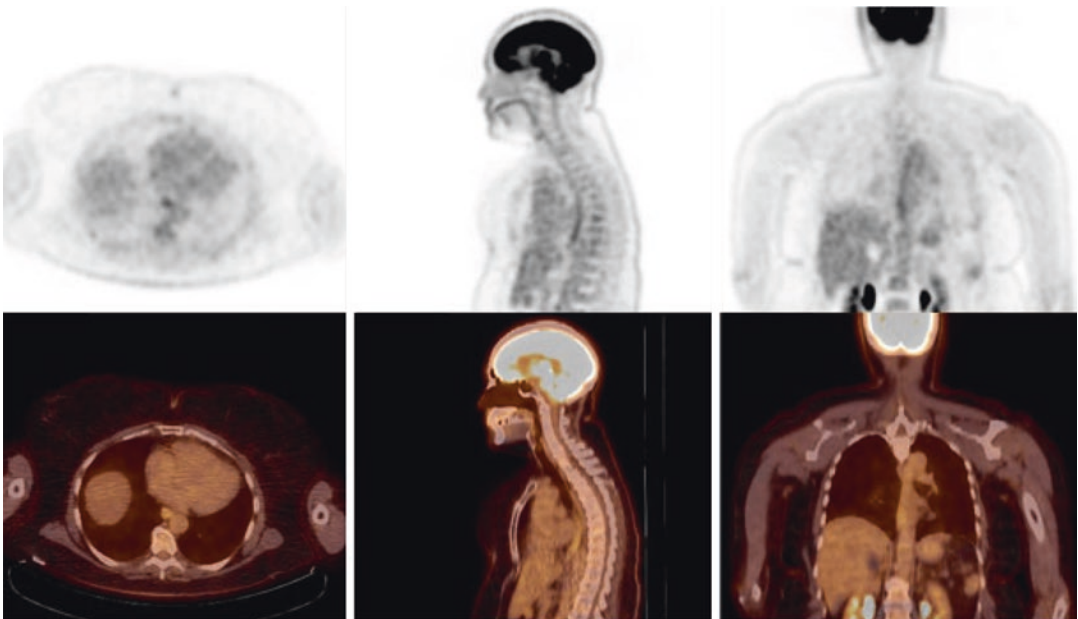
A 63-year-old female with a history of meningioma. FDG PET/CT images show mild liner activity along the mid- and distal esophagus related to esophagitis from gastroesophageal reflux disease
